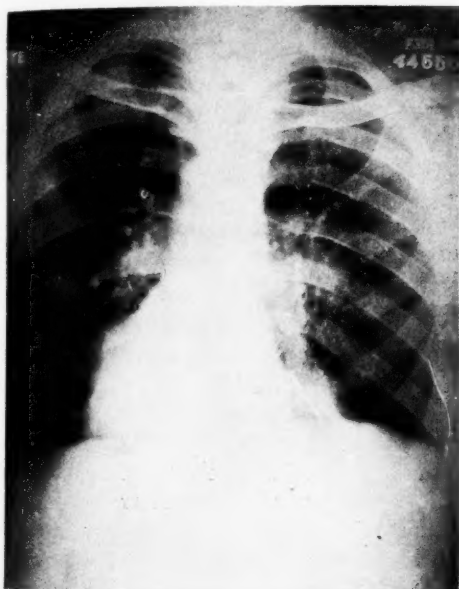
(Case A445586). Roentgenogram of the chest revealing a nail in a descending bronchus of the right lung.
